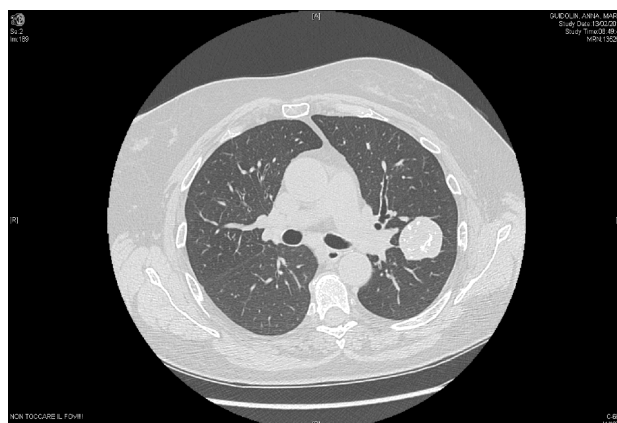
Contrast enhanced CT scan showing a lesion of about 32 mm of diameter, within the lingula. The lesion presents several calcification in its context.
